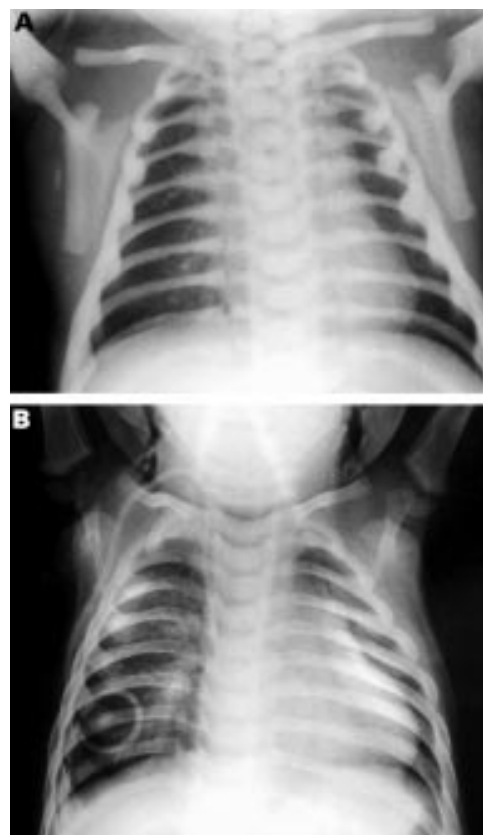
Representative chest radiographs before and after successful unrelated donor bone marrow transplantation. At diagnosis (A) there is generalised osteosclerosis. There is appreciable improvement in both bone density and modelling by nine months after the transplant (B).
